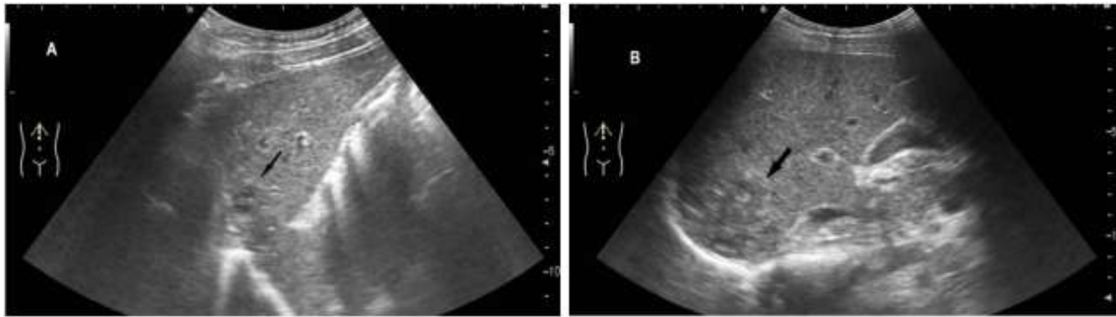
Sonograms show multiple small subcapsular, confluent, ill-defined hypoechoic nodules (arrow).
